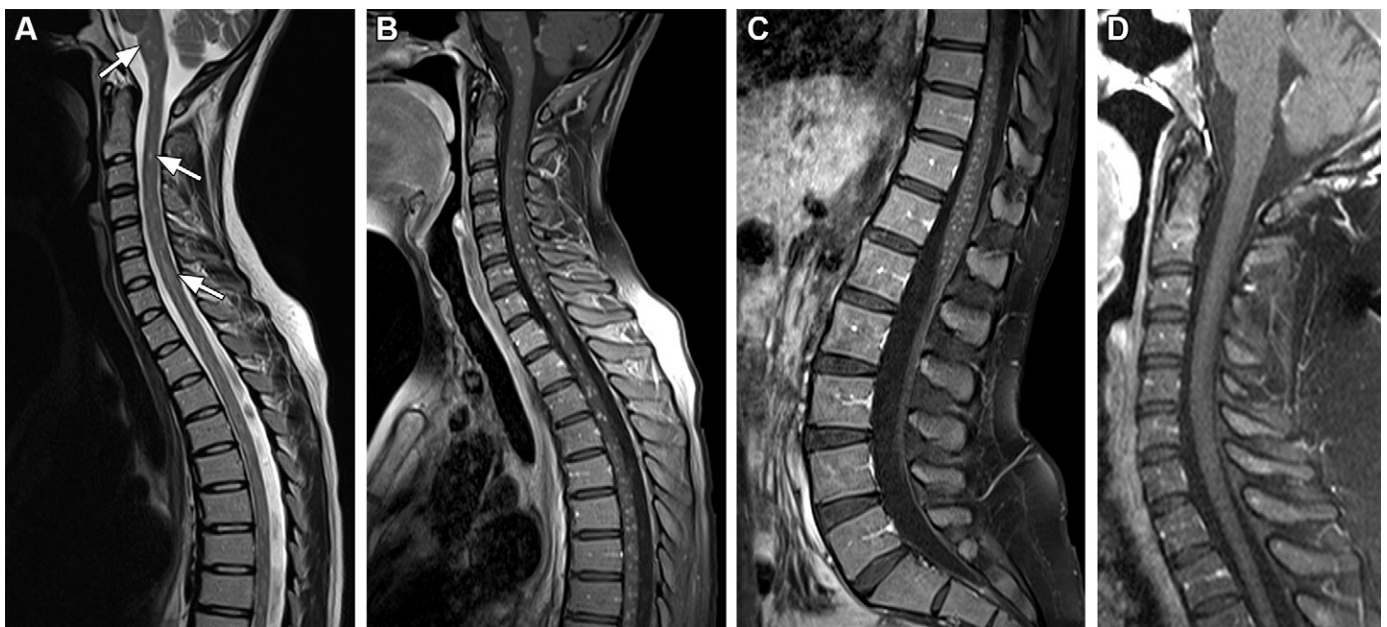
Neurosarcoidosis in a 17-year-old adolescent girl. (A) Sagittal T2-weighted MR image shows multiple subtle hyperintense cord lesions (arrows). (B, C) Sagittal postcontrast T1-weighted MR images show intramedullary holocord micronodular contrast enhancement. (D) Sagittal postcontrast T1-weighted MR image acquired after corticosteroid therapy shows no contrast-enhancing lesion in the cervical spinal cord.
